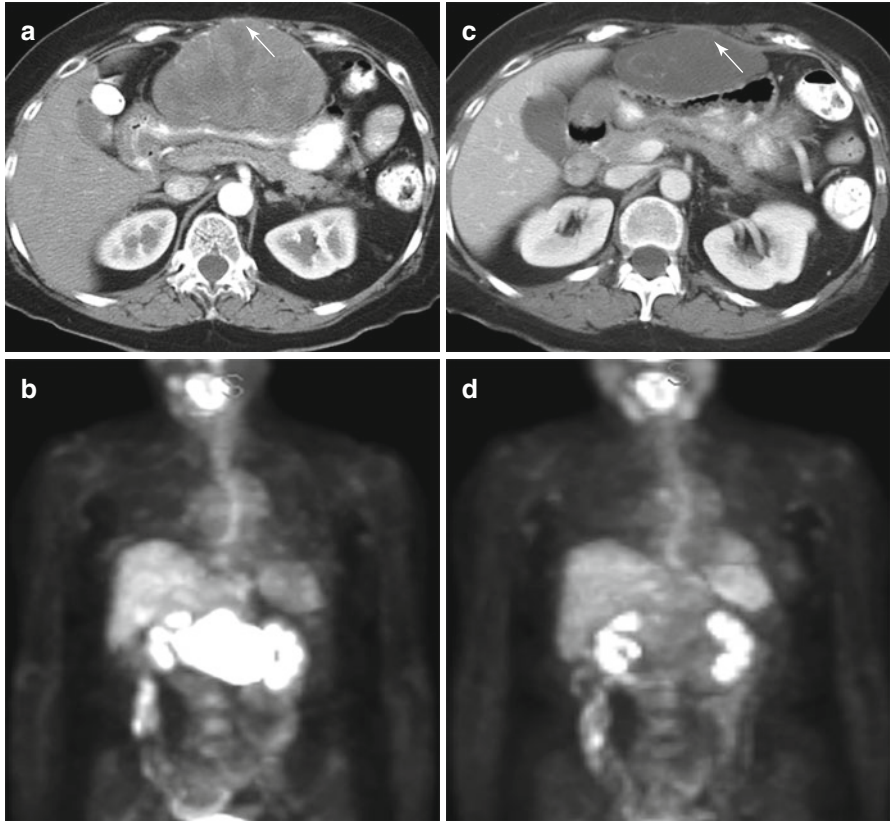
GIST responding to tyrosine kinase inhibitor therapy in a 59-year-old woman with recurrent gastric GIST in the omentum. (a, b) Pretreatment contrast-enhanced CT scan, (a) shows a large, enhancing omental mass abutting the anterior surface of the stomach corresponding to the mass (arrow) with markedly increased glucose uptake shown on pretreatment FDG-PET (b). (c, d) Contrast-enhanced CT scan (c) obtained 2 months after treatment showed that the mass (arrow) has decreased in size and become homogeneous, with a marked decrease in CT density and no appreciable glucose uptake shown on FDG-PET (d) obtained at the same time
